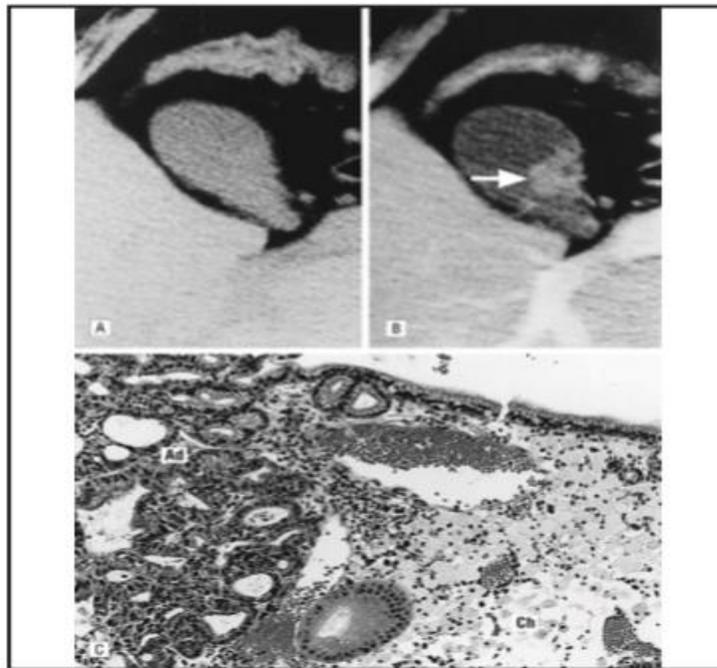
CT Scan showing GB Polyp
